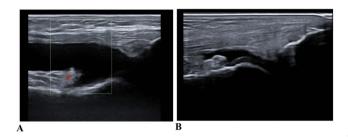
A) Ultrasound evaluation of knee synovitis with severe joint effusion, moderate synovial hypertrophy and positive power-Doppler observed at baseline; B) substantial improvement of synovitis 3 months after starting upadacitinib.
